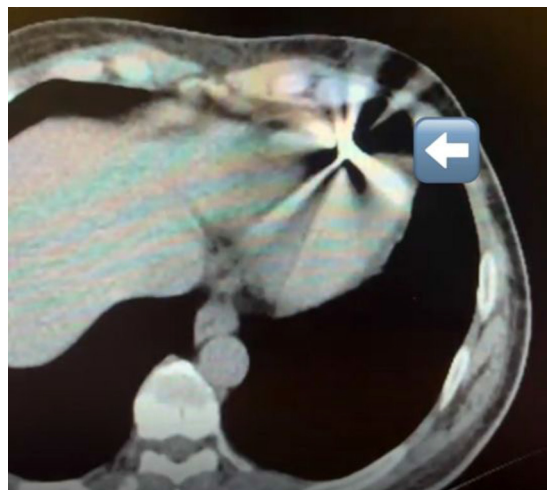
Computed tomography shows foreign body in cardiac apical (white arrow).
